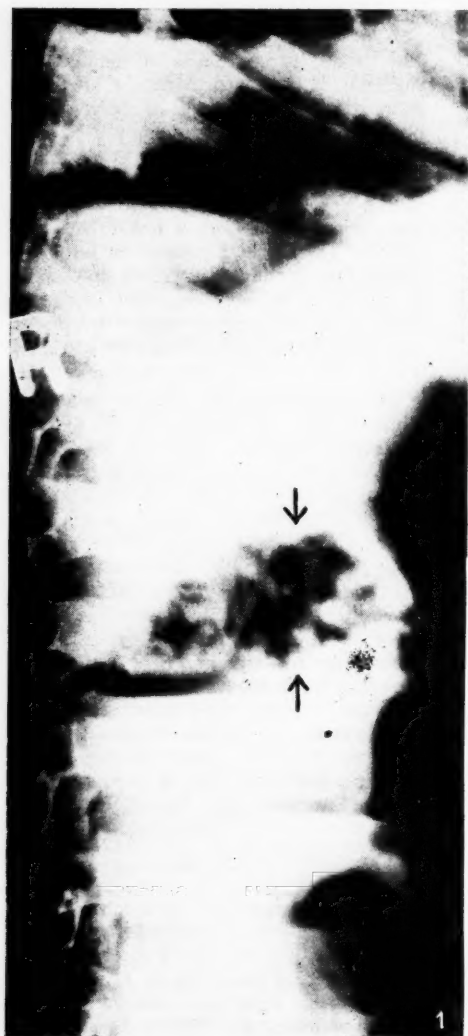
A lateral scout X-ray showing a mass of worms (arrows) and fluid levels (lower right-hand corner).
